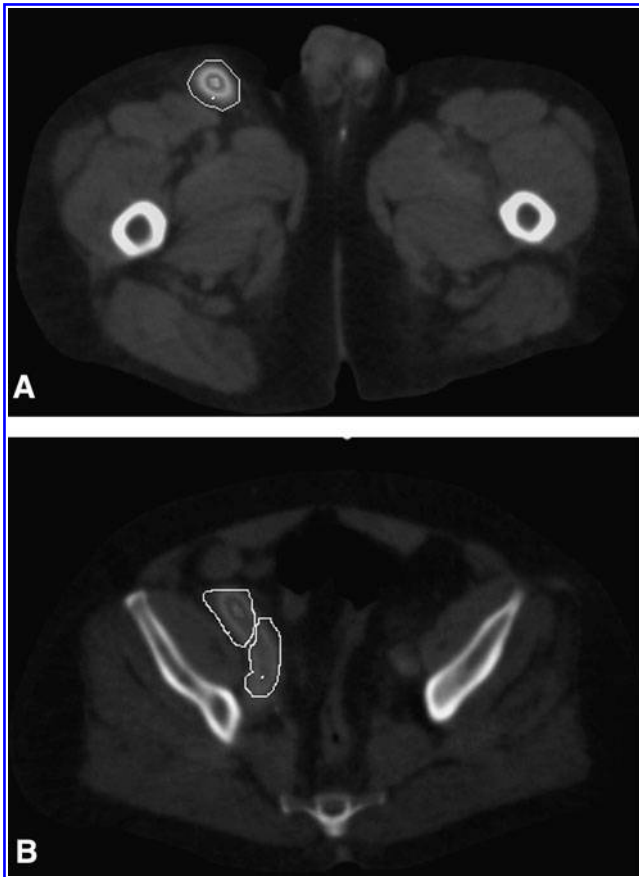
SPECT/CT images with outlines for inguinal tumor (A), anterior iliac tumor (B, upper outline), and posterior iliac tumor (B, lower outline). Images are for subject 10 in Table 1.
